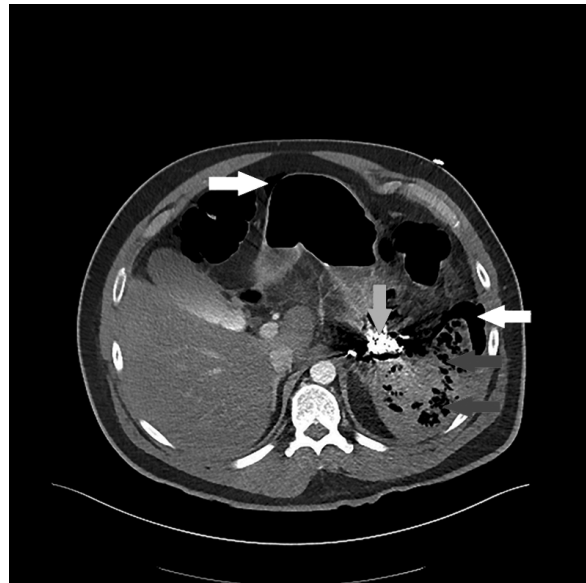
CT-scan (day 3) following clinical deterioration. Pneumoperitoneum (white arrows), coils (lightgray arrow), and intra-splenic air collection (darkgrey arrows) is indicated
